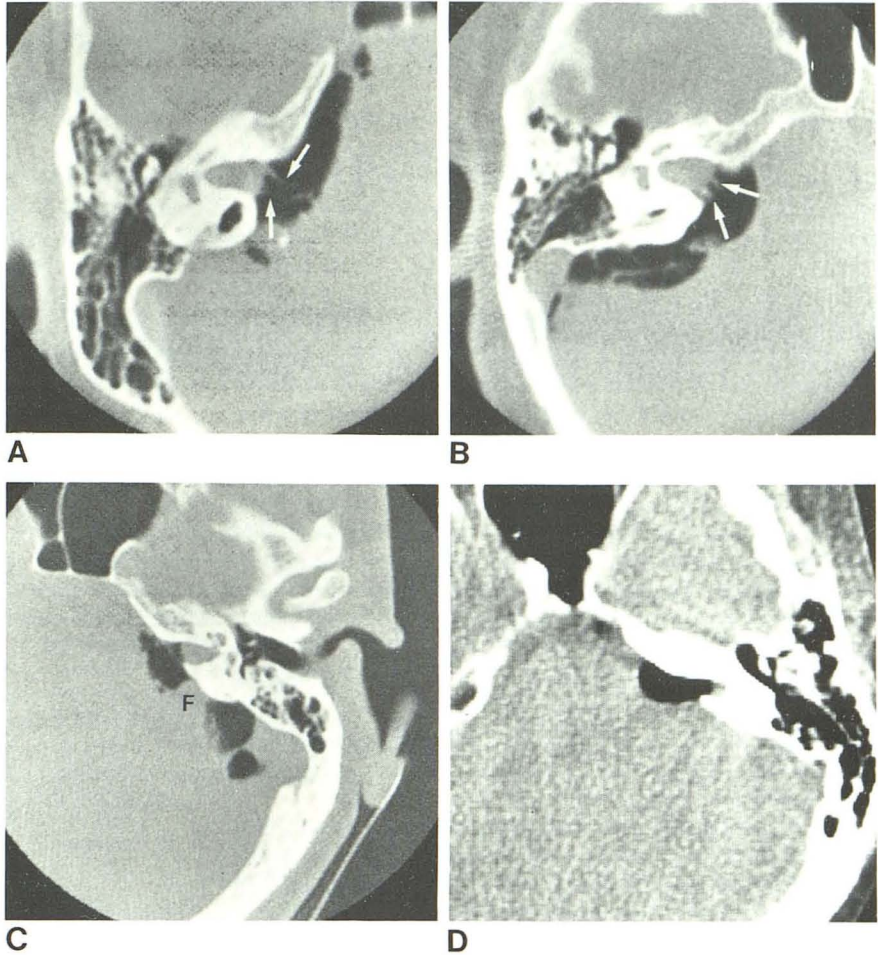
Intra- and extracanalicular acoustic neuroma. Gas within left cerebellopontine angle cistern caps small cisternal mass, which has enlarged internal auditory canal at porus acusticus. Mass extends about 5 mm from porus acusticus. Routine contrast-enhanced CT scan was suspicious because of asymmetric canal enlargement, but no enhancing tumor was demonstrated.
